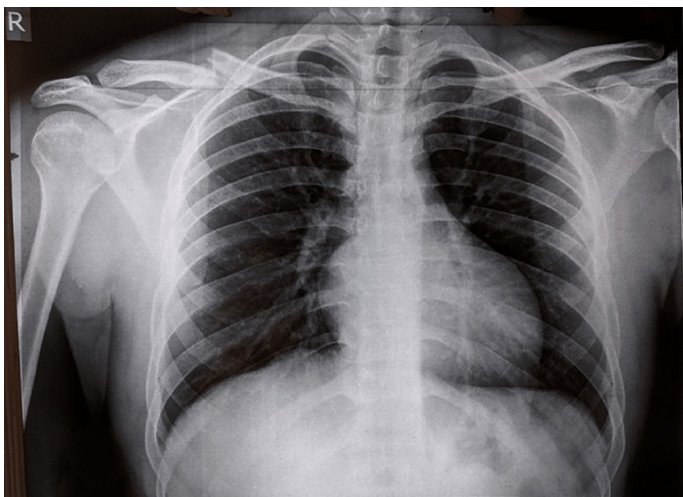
Pre-operative X-ray showing mid-shaft clavicle fracture
